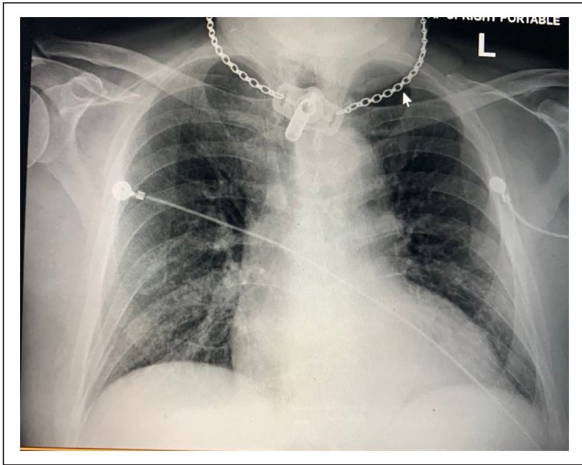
Chest X-ray AP view showing bibasilar opacities likely atelectasis and less likely developing pneumonia.
